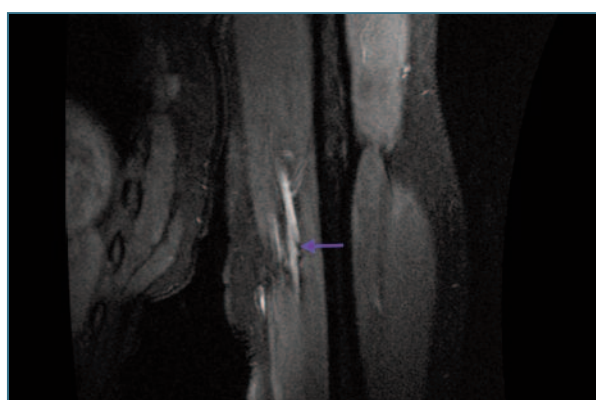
Left upper limb MRI. Longitudinal section.
